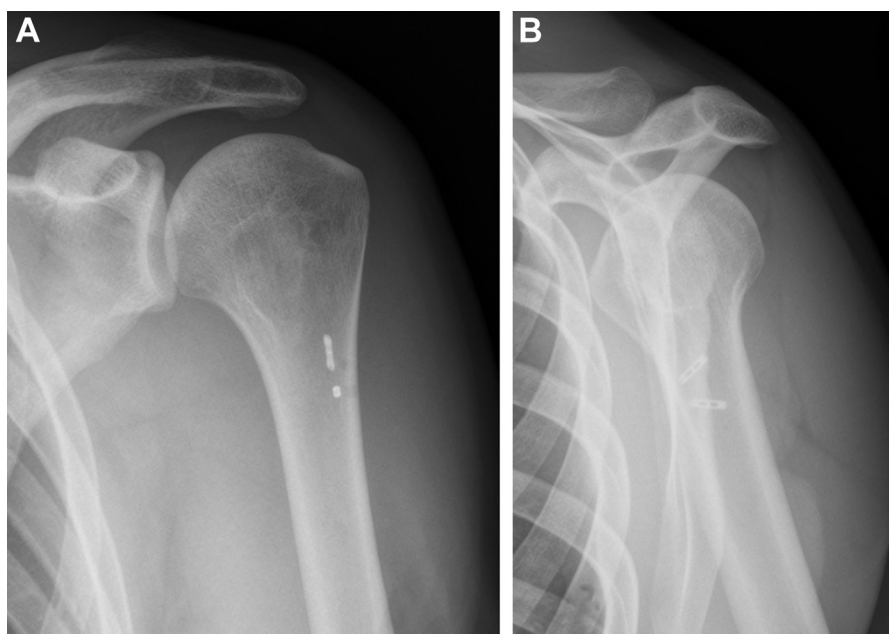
(A, B) Radiographic imaging showing buttons deployed within intramedullary canal of left humerus.
